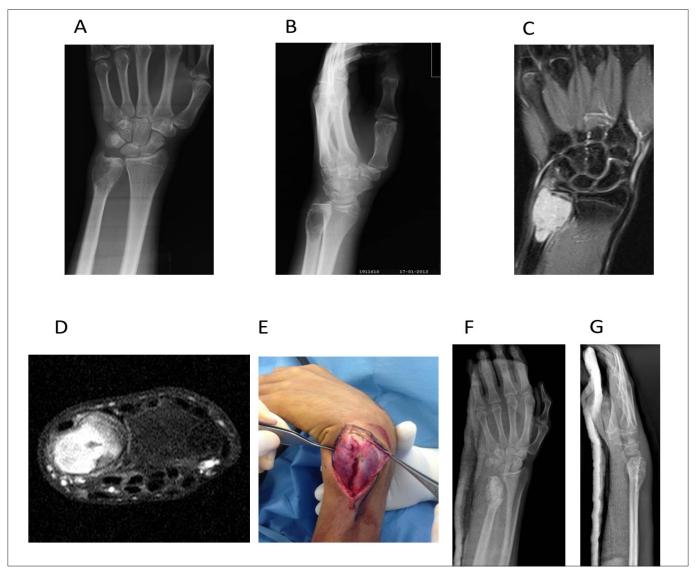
A 28-year-old male with distal ulna aneurysmal bone cyst a,b) preoperative plain radiograph, c,d) preoperative magnetic resonance image, e) the patient underwent curettage followed by grafting, f,g) postoperative plain radiograph.
